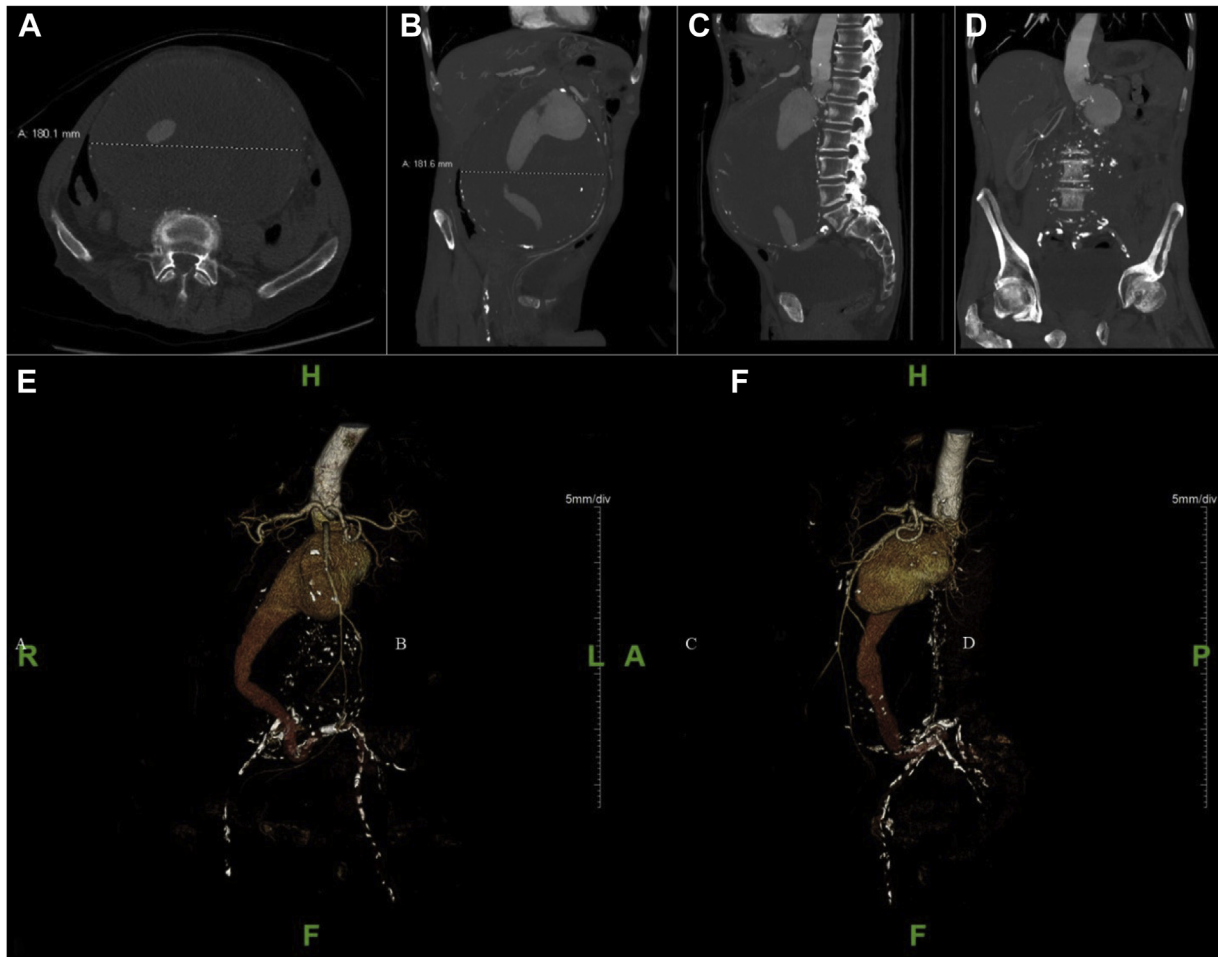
Preoperative computed tomography angiograms demonstrating an 18-cm abdominal aortic aneurysm (AAA) with severe neck angulation. A, Axial imaging study demonstrating a maximum diameter of 18 cm and large amount of intramural thrombus. B, Coronal imaging study demonstrating maximum diameter of 18 cm. C, Sagittal imaging study demonstrating aortic neck angulation. D, Coronal imaging study demonstrating aortic neck angulation. E, Anteroposterior view of preoperative computed tomography angiogram with three-dimensional reconstruction. F, Lateral view of preoperative computed tomography angiogram with three-dimensional reconstruction.
